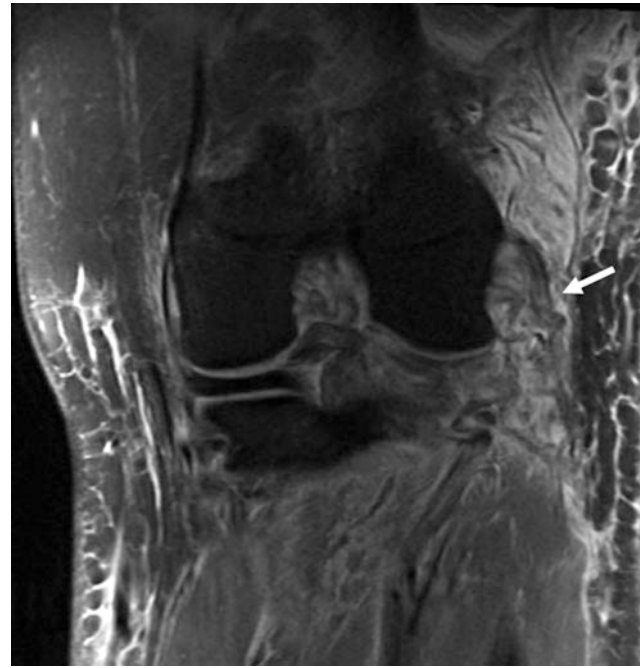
Coronal MRI demonstrating midsubstance LCL injury (white arrow) causing laxity and proximal retraction of the ligament. Associated PLC injury is also noted
